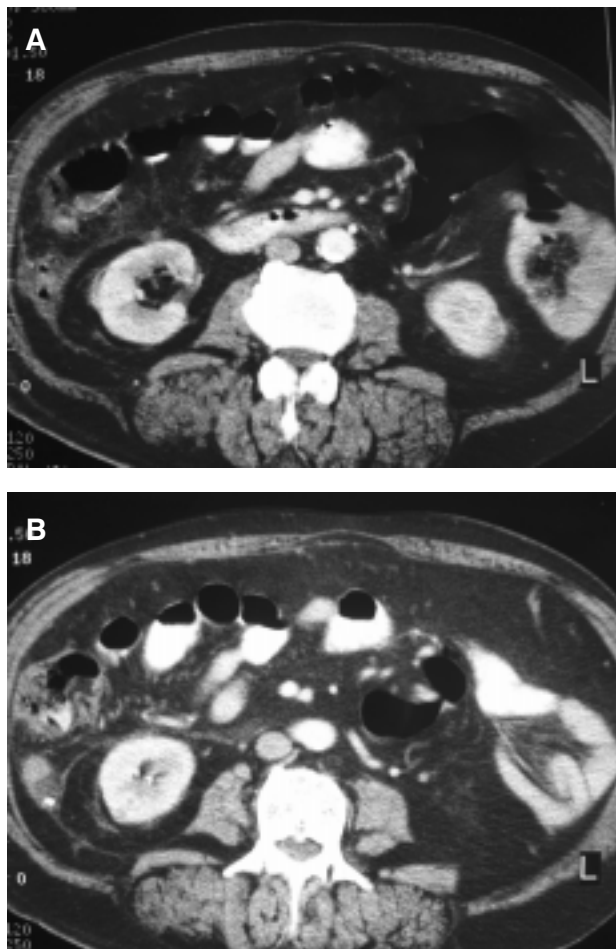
Spiral abdominal CT: demonstration of significant appendiceal enlargement with intraluminal calcified fecalith and wall thinning. Diagnosis: acute gangrenous appendicitis.
